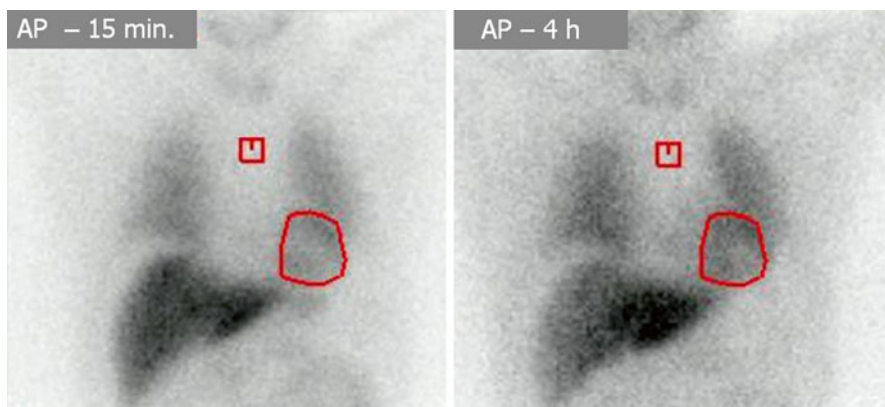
43-year-old hemodialysed male patient, [^{123}I]-MIBG scintigraphy in planar anterior projection, performed in two point of time - 15 minutes and 4 hours post injection of radiotracer. The global indices of CSNS activity are within the normal range: early H/M = 2.15, delayed H/M = 2.12, and WR = 21.7 %. In red color the region of interest (ROI), which are needed for H/M ratio calculation, of mediastinum (*square*) and heart (*elliptic*) are defined
